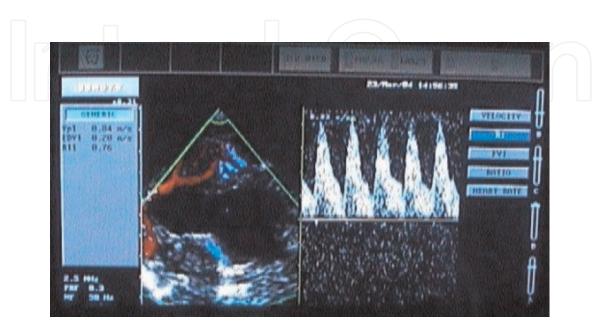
The Doppler curve of blood flow in ACA of the infant with schizencephaly before ventriculoperitoneal shunt insertion. The value of RI-ACA is increased due to decrease of Ved.
